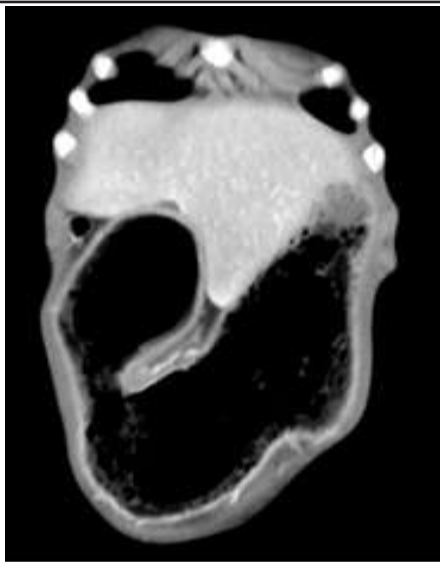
CT scan, showing dilated stomach and duodenal loops.
